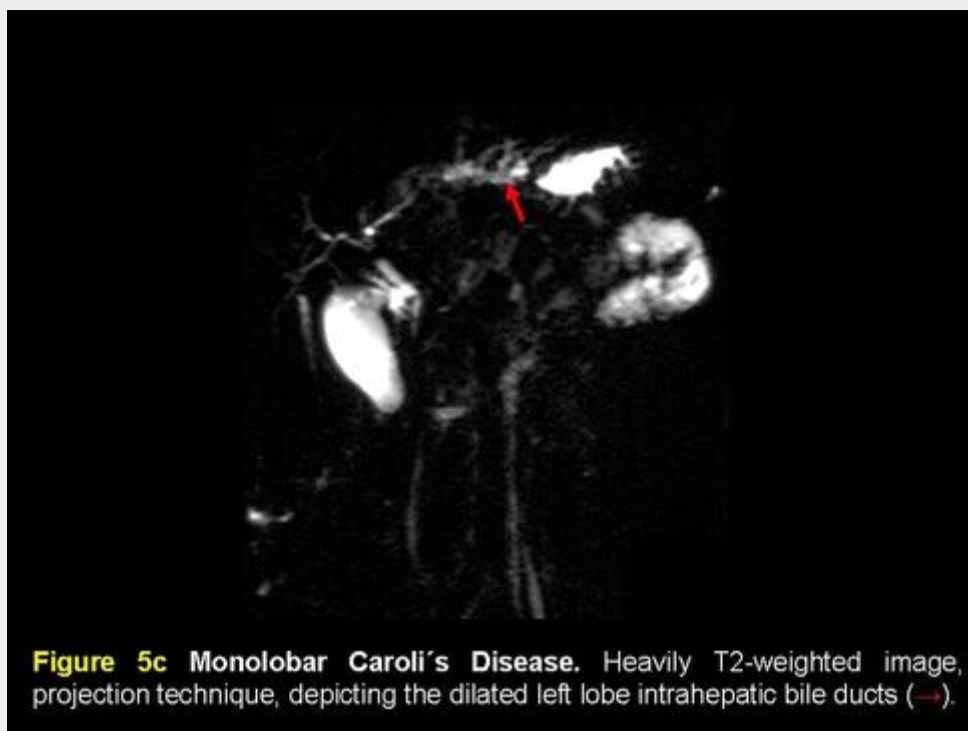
Monolobar Caroli's Disease. Heavily T2-weighted image, projection technique, depicting the dilated left lobe intrahepatic bile ducts (→).
